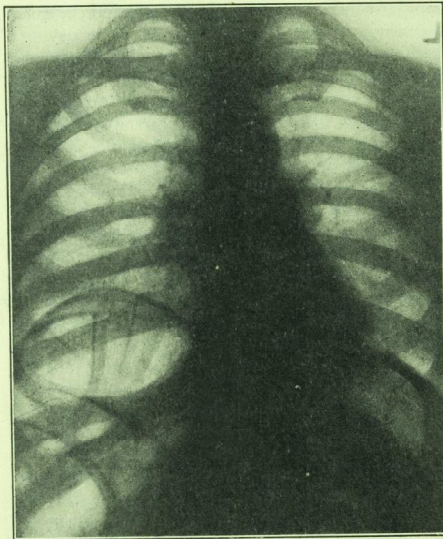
X-RAY OF CHEST SHOWING REPLACEMENT OF LIVER SHADOW BY COILS OF LARGE INTESTINE.
